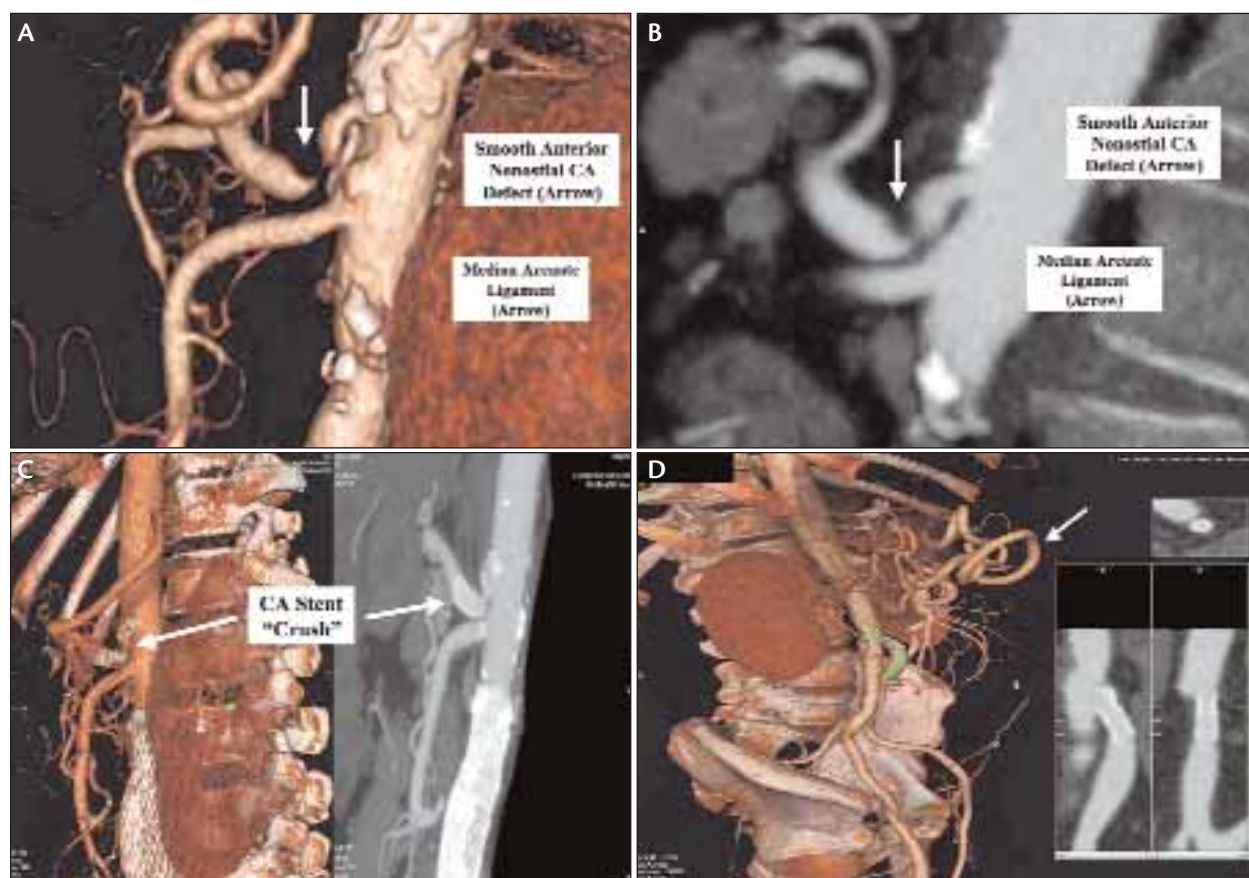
CTA demonstrating smooth anterior defect in the proximal CA suspicious for median arcuate ligament compression (A,B). CTA in a post-EVAR and CA-stent patient demonstrating CA stent crushing (C). IMA stent demonstrates no ISR at 2 years. Note total occlusions of the CA and SMA and large collateral of Drummond (arrow) (D).
